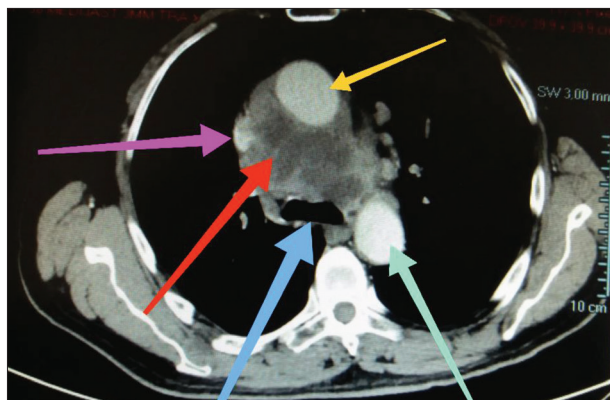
Computed tomography scan of mediastinal lymphadenopathy at the level of tracheal carina; pink arrow – inferior vena cava; red arrow – lymph node conglomerate; blue arrow – tracheal carina; green arrow – descending aorta; yellow arrow – ascending aorta
